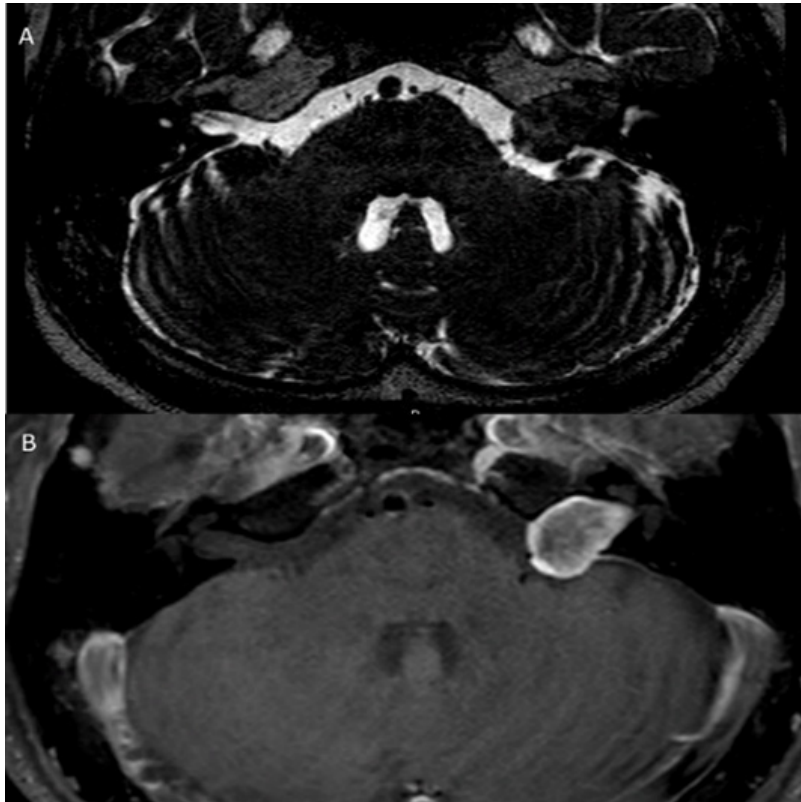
(A) Axial CISS image shows the tumor totally occupied and expanded to the left internal auditory canal (IAC). Its margin is inaccurately separable from the left temporal bone and inner ear structures without CSF signal outlining. (B) Axial postcontrast T1-weighted image clearly depicts the well-defined tumor.
